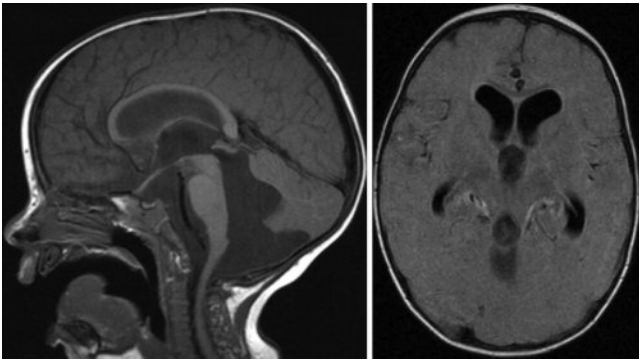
Magnetic resonance images obtained at the patient's initial presentation. *Left:* Sagittal T1-weighted image demonstrating cerebellar vermal hypoplasia and gross enlargement of the fourth ventricle, consistent with DWC. *Right:* Axial T1-weighted image demonstrating hydrocephalus without aqueductal obstruction.
